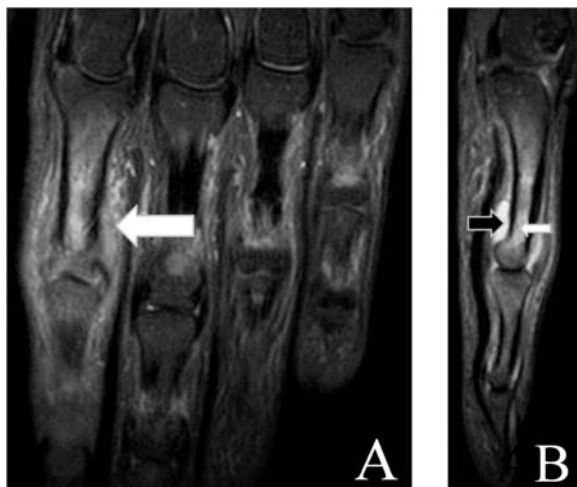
Sagittal (A) and axial (B) short tau inversion recovery (STIR) magnetic resonance images of the 4th finger. Arrows mark periarticular inflammation.
